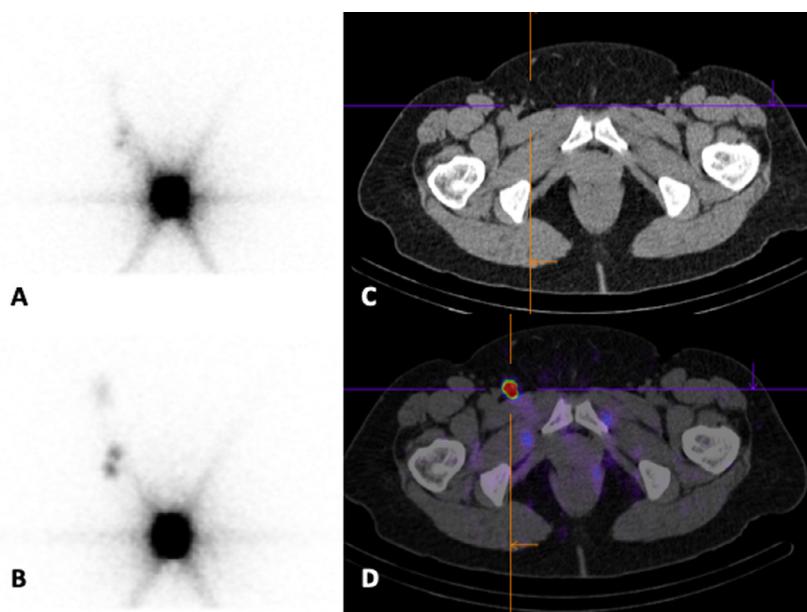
A 53-year-old woman, before surgery for vulvar carcinoma, underwent sentinel LN scintigraphy after injection of about 40 MBq of ^{99m}Tc nanocolloid in two peritumoral points, followed by planar images acquisition at 30 minutes and 150 minutes (A and B). Two focal uptakes were observed in planar acquisitions while the SPECT/CT (C-axial view of CT, D-axial view of SPECT/CT fusion) localized the uptakes in two sentinel millimetric right inguinal LNs. Surgery of the right hand side vulvar carcinoma and of right groin sentinel nodes allowed to stage the patient in pT1b N0.
